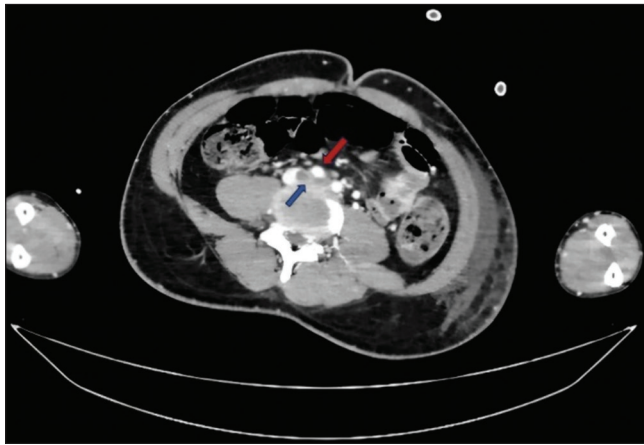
Axial computed tomography venogram showing May-Thurner syndrome with iliofemoral deep vein thrombosis. The red arrow indicates compression of the left common iliac vein by the right common iliac artery, and the blue arrow indicates an obstructive thrombus in the left iliac venous system
